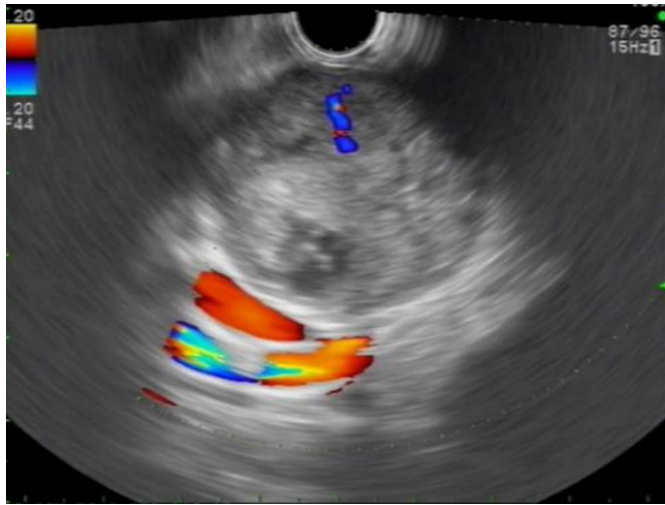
Endosonography of the pancreatic lesion revealed a heterogeneous hypoechoic tumoral mass in the pancreatic head, with a smooth contour, containing anechoic cystic areas, and vascular flows were observed in the Doppler examination.
